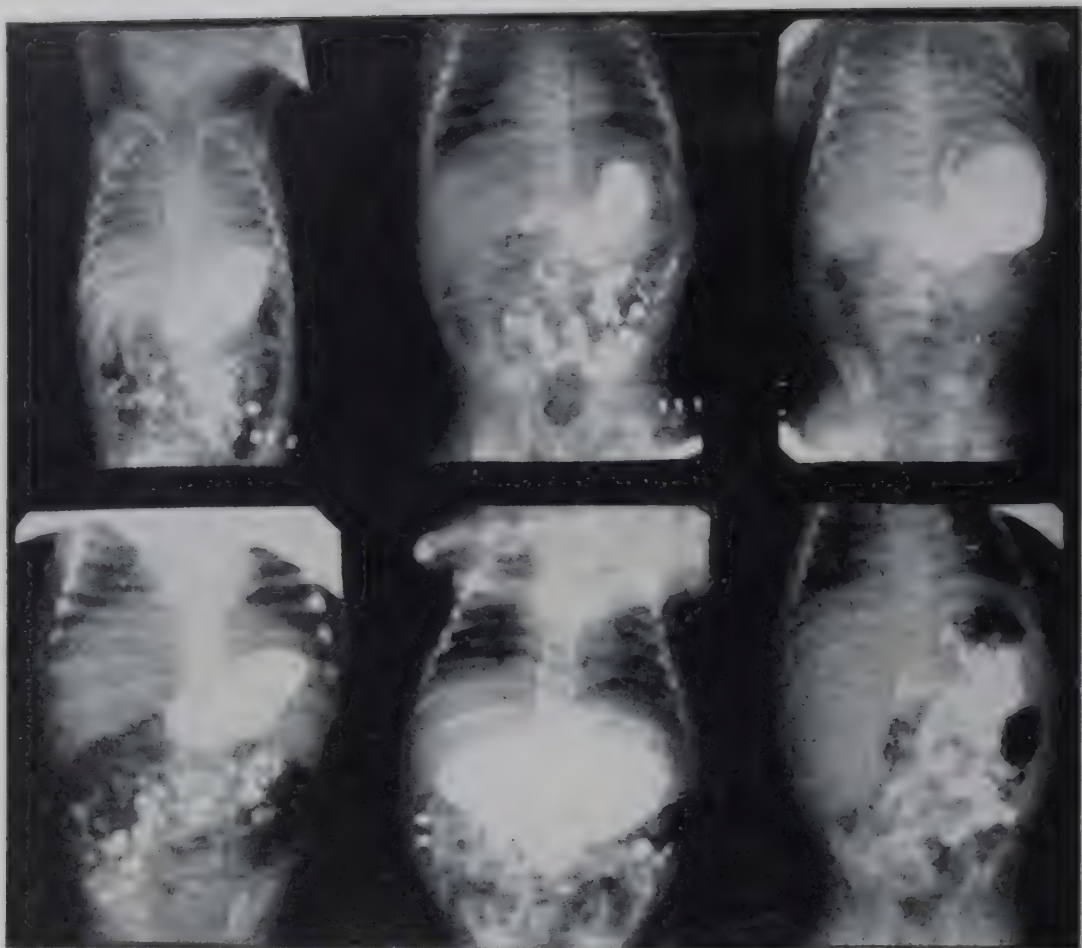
Roentgenograms of stomachs of 6 infants 3 weeks to 4 months old, showing different sizes and shapes. (Bouslog, T. S., and others: J. Pediat., vol. 6.)
